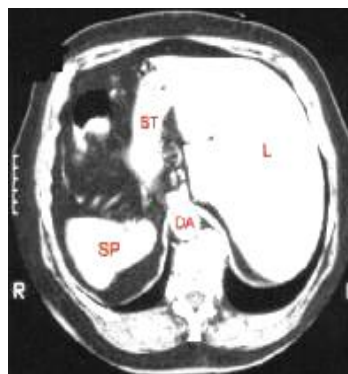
CT scan showing reversal of normal anatomy
